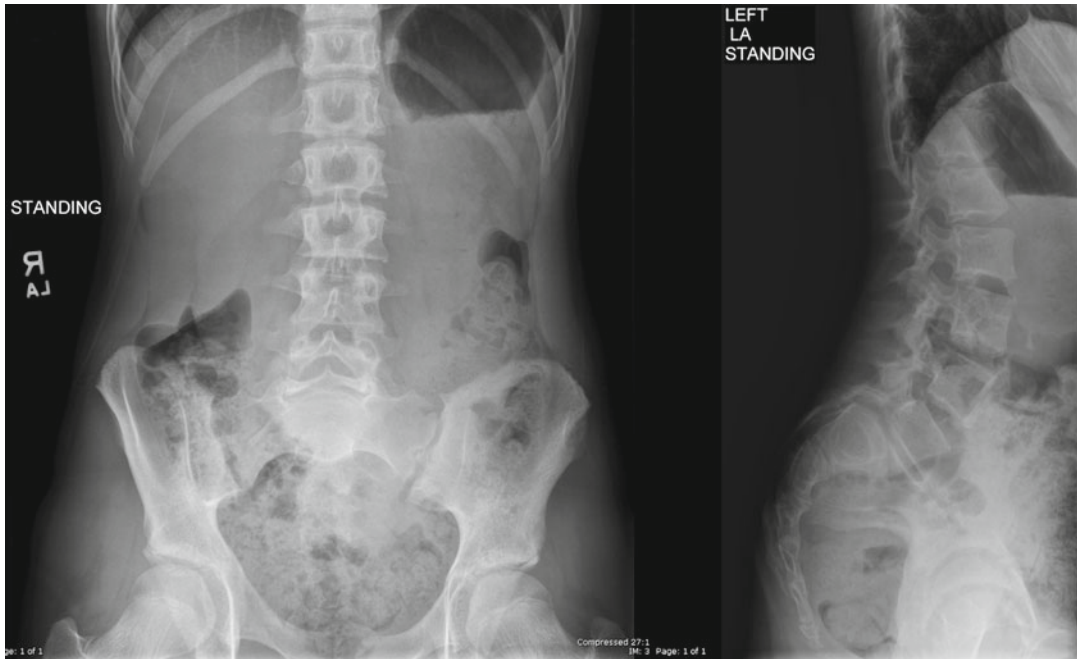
AP and lateral lumbar spine radiographs demonstrating a grade 3 dysplastic spondylolisthesis. Note the elongated pars interarticularis of L5 without isthmic defect
